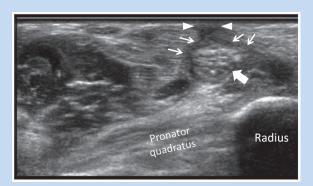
Sonographic evaluation of the median nerve in a patient with hand numbness and prior plate fixation of the distal radius. Transverse ultrasound image at the distal forearm reveals hypoechoic scar tissue extending from the skin (arrowheads) to the volar surface of the median nerve (arrows), in keeping with scar tethering. The median nerve (block arrow) in this region is abnormally enlarged and has prominent internal fascicles, consistent with neuritis.
